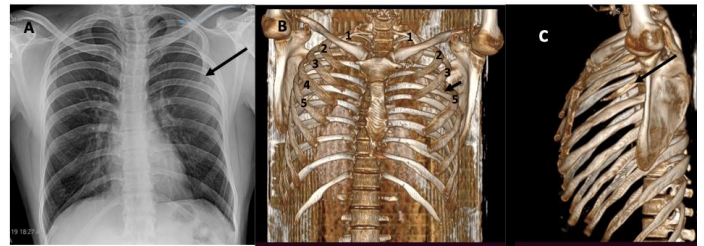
HYPOPLASTIC RIB (Short rib). A- Chest Xray PA View, B- three-dimensional reconstruction image of computed tomography chest; C- three-dimensional reconstruction image of computed tomography chest left lateral view. Showing hypoplasia of the left fourth rib (Black arrow).
